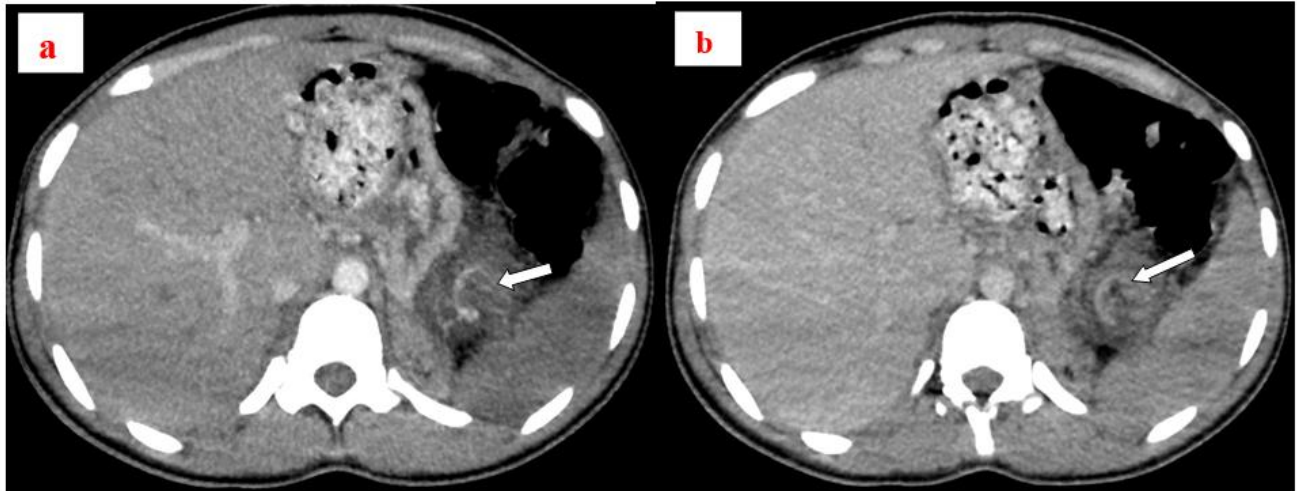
Arterial (a) and portal (b) phase CT images showing a whirl sign (arrow) of the splenic pedicle, associated with stranding of the perisplenic fat
